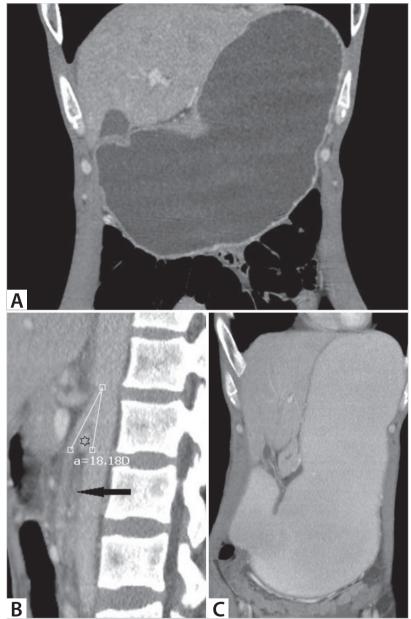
A. Preoperative coronal CT image shows gastric dilatation. B. Sagittal CT scan shows narrowing of the aortomesenteric angle and reduction of the aorta-SMA distance. C. CT image shows gastric ptosis and gastroparesis after initial surgery (Patient 2).
